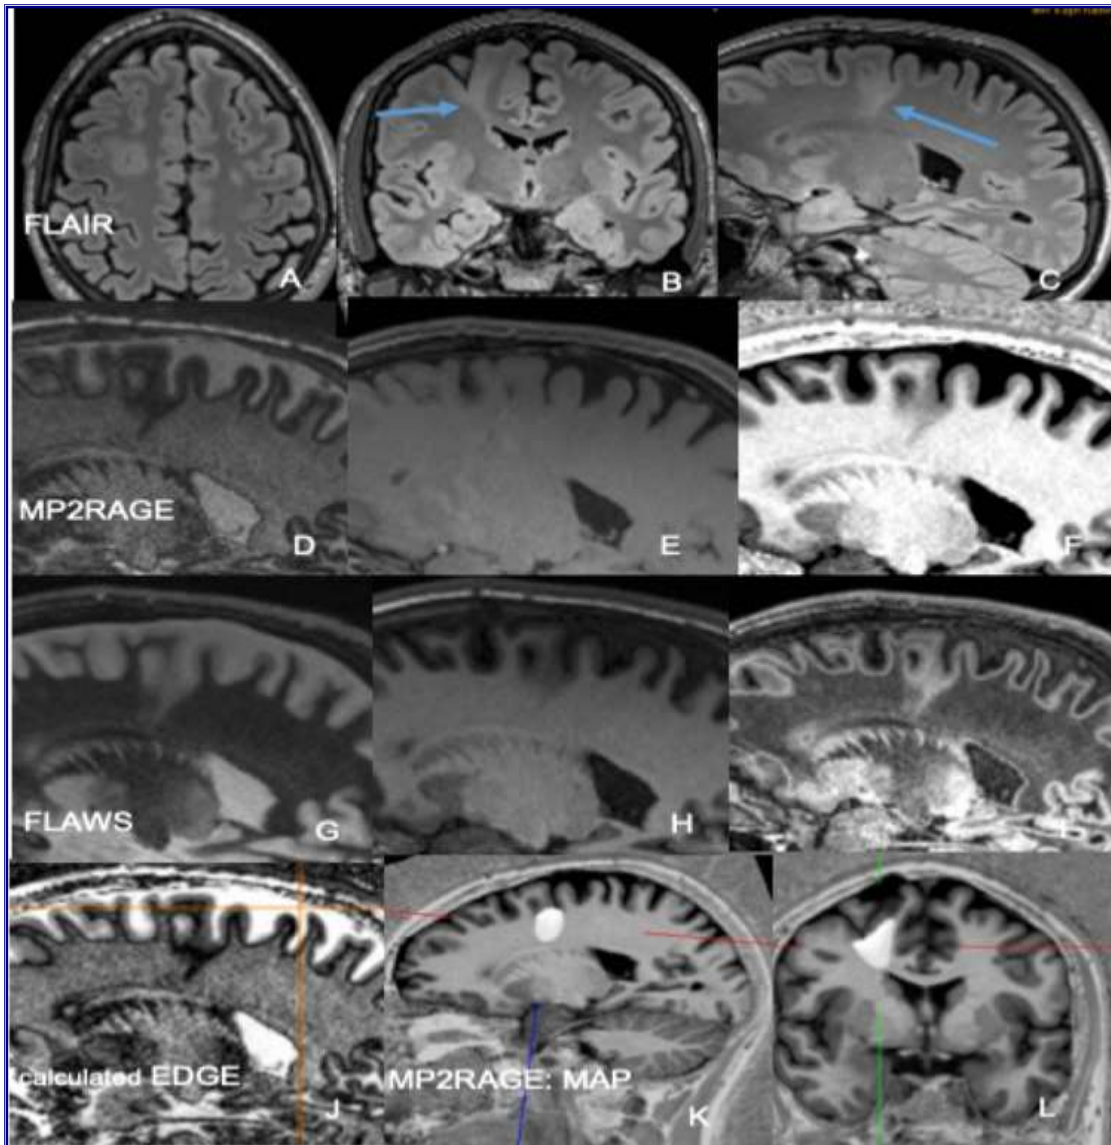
FCD type IIb in the depth of the right superior frontal sulcus. A–C 3 Tesla axial, coronal, and sagittal 3D FLAIR SPACE images show a thickened cortex and a hyperintense transmantle sign tapering towards the frontal horn of lateral ventricle (B, C: arrow). D–F 3 Tesla sagittal MP2RAGE images at inversion times TI of 700 ms (D) and 2500 ms (E). Calculated so-called unified image (F). G–I 3 Tesla sagittal FLAWS images at inversion times TI of 409 ms (G) and 1160 ms (H). Calculated minimum intensity image (I). J 3 Tesla calculated sagittal EDGE image at an inversion time of 442 ms according to Bydder and Young (1995) and Hornak (2008). K–L MAP-postprocessed MP2RAGE images after inverse normalization and co-registration of the CNN output map to the unified images (12).
